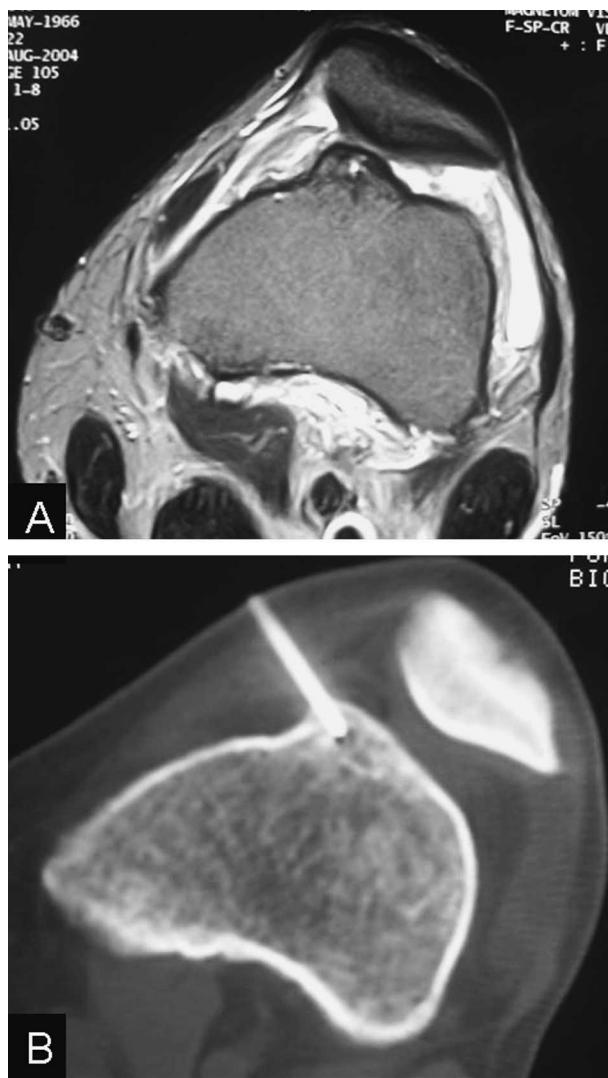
Preoperative images of a 30-year-old man with pain and frequent locking symptoms show an osteochondroma of the trochlea. (A) An axial magnetic resonance image shows the exostosis located in the trochlea that subluxates the patella. (B) An axial computed tomography image at the moment of the needle biopsy confirms the diagnosis of osteochondroma.
